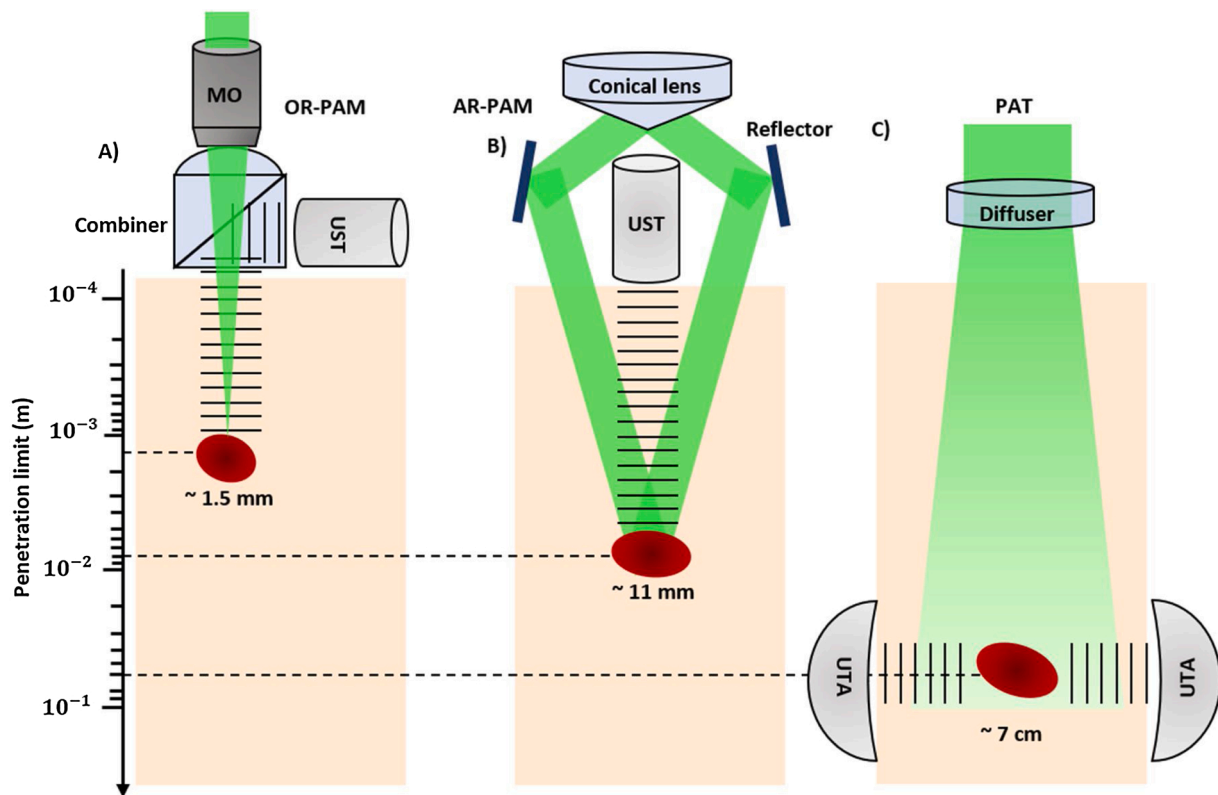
Signal generation and detection in different implementations of PAI with different penetration limits in scattering tissue. These depths values are the maximum depths reported in the literature. (a) Reflection-mode OR-PAM system with an optical-acoustic combiner that transmits light but reflects sound. OR-PAM system with 1.5 mm imaging depth was reported [65]. (b) AR-PAM system where the laser light is only weakly focused, previous work demonstrated 11 mm imaging depth in biological tissue [61]. (c) PAT system with a ring-shaped ultrasonic transducer array (UTA). The laser beam is expanded and homogenized by a diffuser to provide widefield illumination. Recent research has proved 7 cm imaging depth achieved in biological tissue [40].
